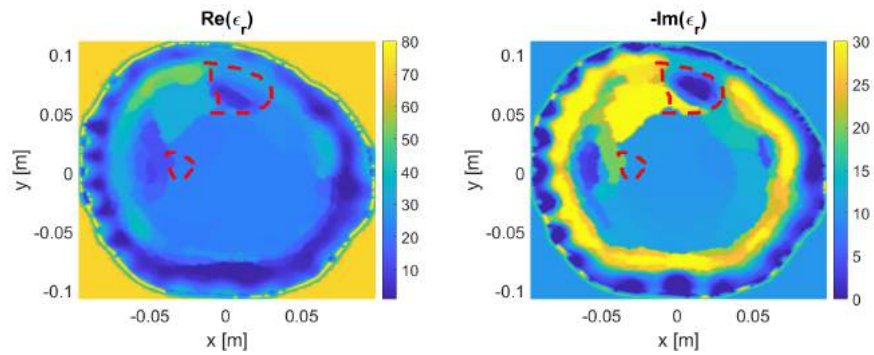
The effect of using ultrasound gel as matching medium for MRI model 1
